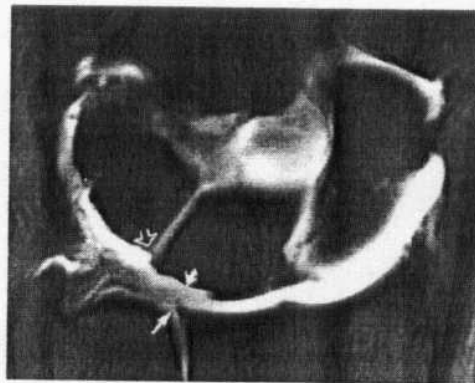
Fat-suppressed T1-weighted coronal arthrographic image demonstrating class IID injury with perforation of TFC (straight arrow), loss of lunate articular cartilage (curved arrow), and lunotriquetral ligament disruption (open arrow). The intrasubstance enhancement of the TFC is commonly seen in degenerative lesions (Quoted from Stoller and Brody, 1997).
